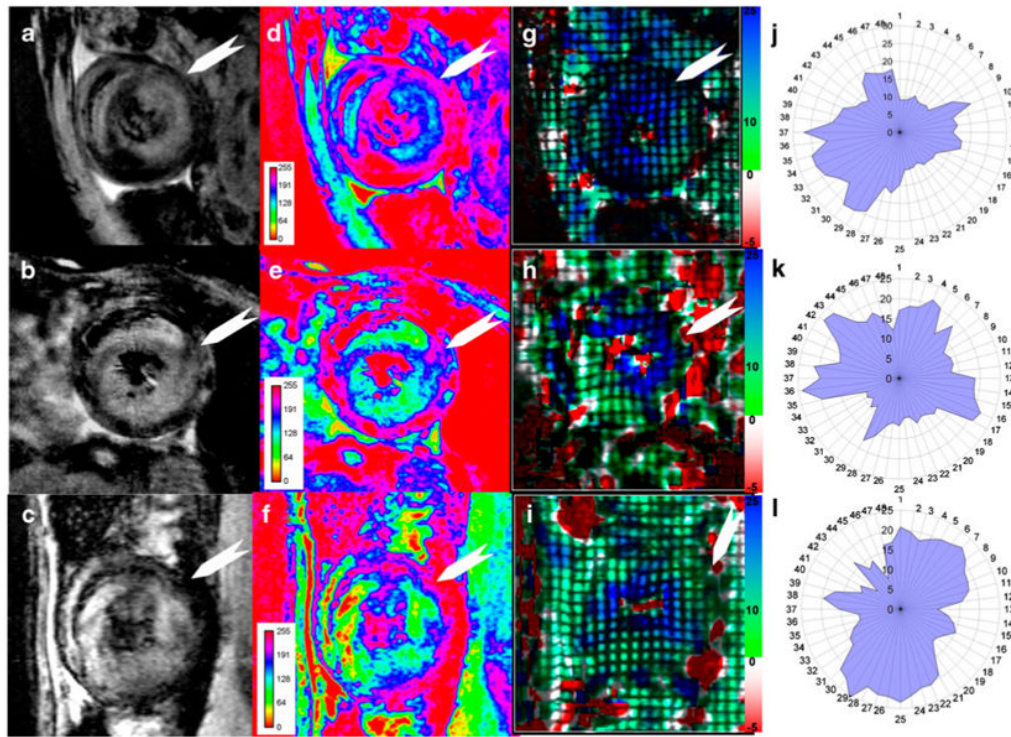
Simultaneous tracking of cellular infiltration and function for 3 allografts: a–c, T_2^* -weighted MRI; d–f, pseudo-coloring of T_2^* -weighted images with 8-bit signal-intensity scaling; and g–i, Ecc strain maps. Absolute or positive values of Ecc are indicated; j–l, polar plots of $|Ecc|$. *White arrows* indicate the intercepted point of right ventricle and left ventricle, which is the starting location of probe #1. (From Wu et al. [22•]; with permission)
